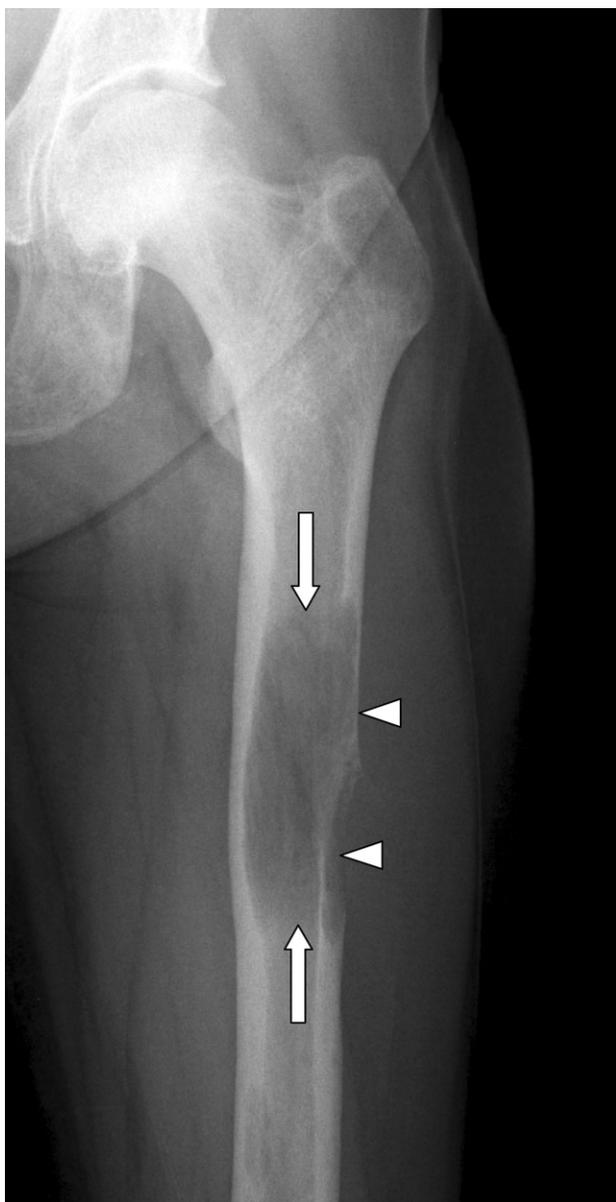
Radiograph of the left femur shows extensive (8-cm height) and discretely expansive lytic lesion within the proximal diaphysis (arrows) with almost complete destruction of the lateral cortex (arrowheads).
